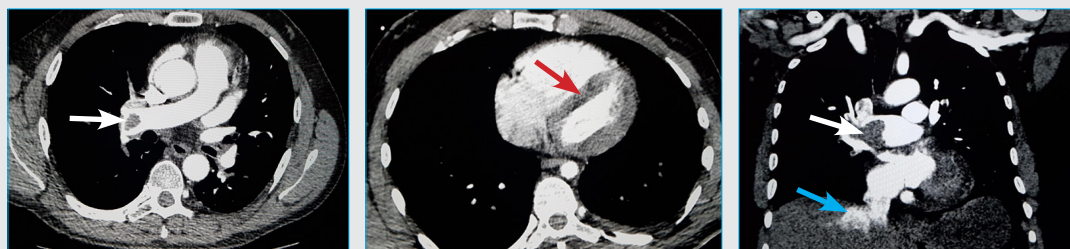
CT pulmonary angio mediastinal window of a patient with COVID-19 and significant O₂ desaturation. (A) and (B) are axial sections while (c) is a coronal section. A & C show a filling defect (white arrows) in the right main pulmonary artery with early visualization of the inferior vena cava (blue arrow) due to reflux indicating high right ventricular pressure. The interventricular septum is pushed to the left ventricle in (B) (red arrow) due to increase right ventricular pressure.
